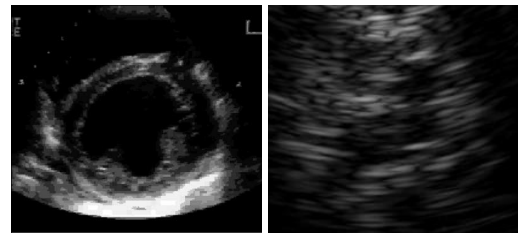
An endocardial (left) and transcranial (right) ultrasound image. The different level of noise is evident.
